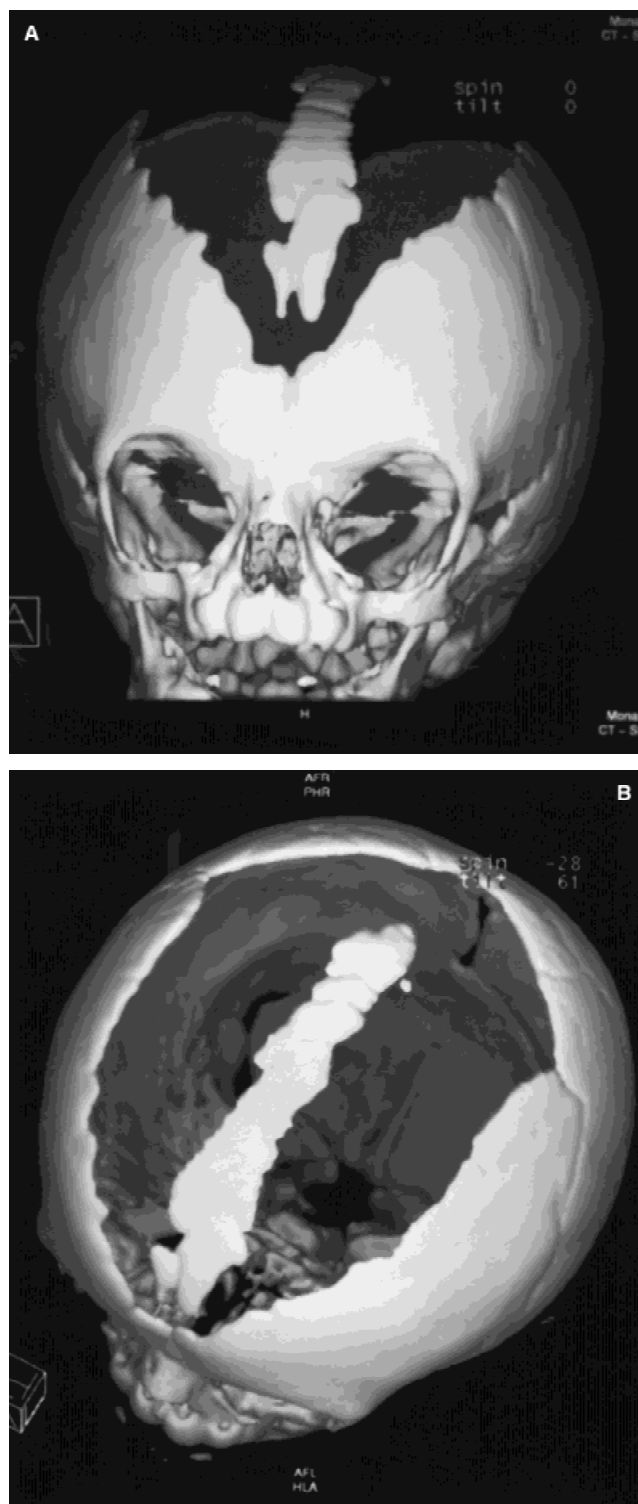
3-D CT reconstruction of the skull vault (A,B), demonstrating craniosynostosis of all sutures except the posterior sagittal suture, and a large U-shaped defect in the bilateral frontoparietal bones.
